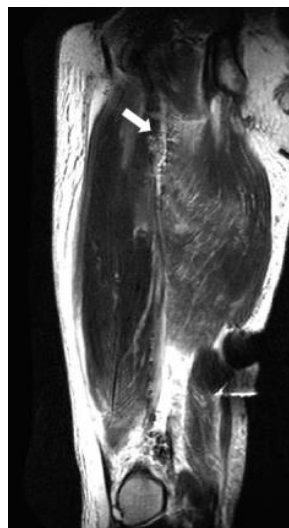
MRI showing multiple very small low signal intensities along the intermuscular septum of right thigh suggesting gas bubble(arrow).
